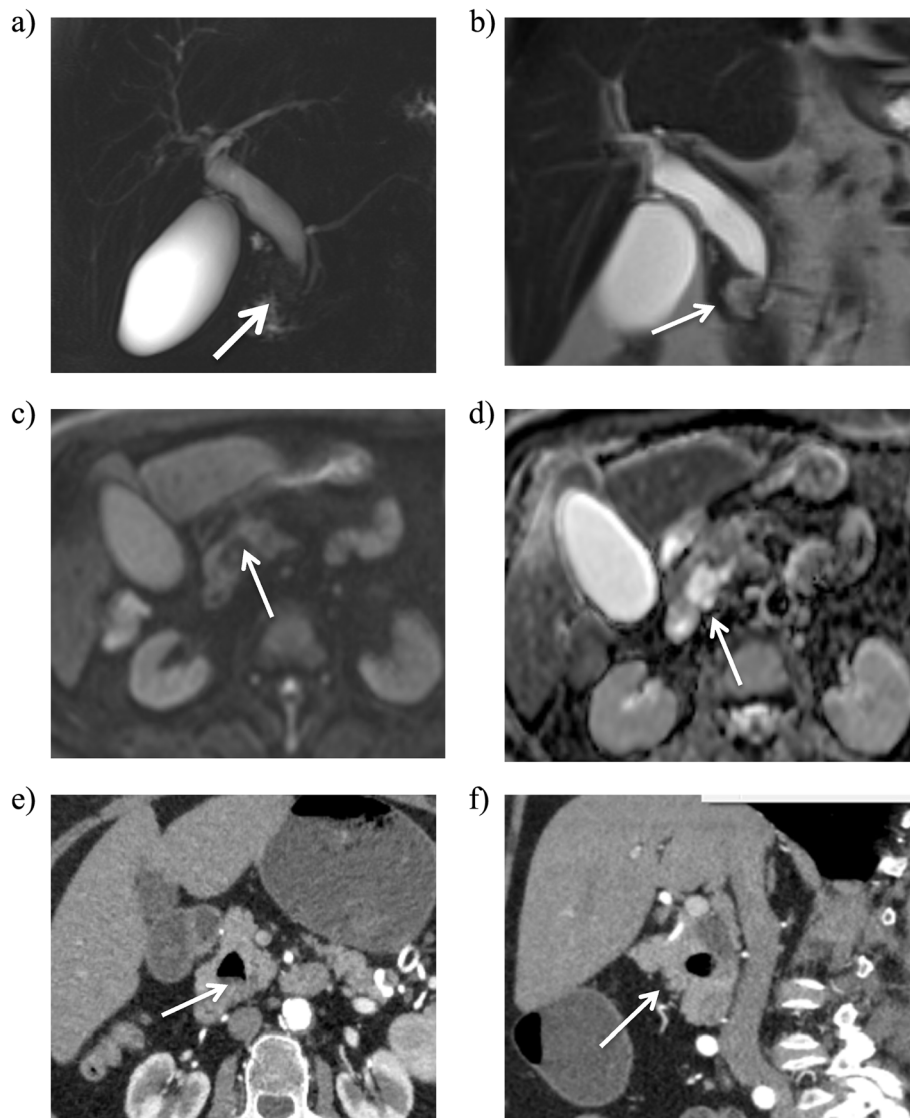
Follow-up study for the same patient three months later. a, b 3D T2 coronal thick slab MRCP and coronal HASTE images showing partial regression of the degree of biliary dilatation (CBD=12 m), as well as the main pancreatic duct (thick arrow) and the biliary stricture (thin arrow). c Initial and follow up axial T2 HASTE images showing resolution of the pancreatic head mass (white arrows). d DWI and ADC map, still showing no diffusion restriction (thin arrows)
